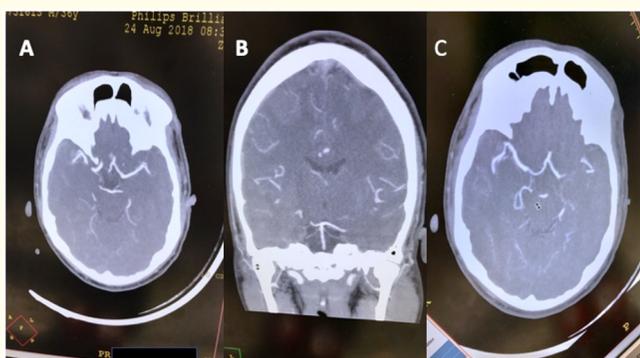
CT angiography (A,B,C) head.
